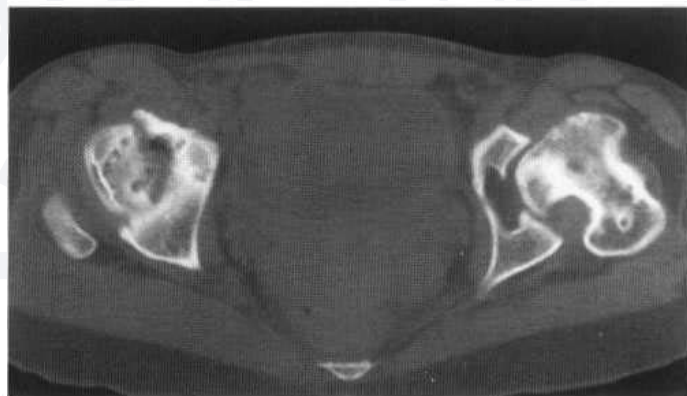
Dysplasia epiphysealis multiplex. At CT scanning the flattening of the femoral heads is confirmed in association with marked irregularity and fragmentation. There is substantial anteversion and uncovering on the left. Muscle atrophy is evident.
